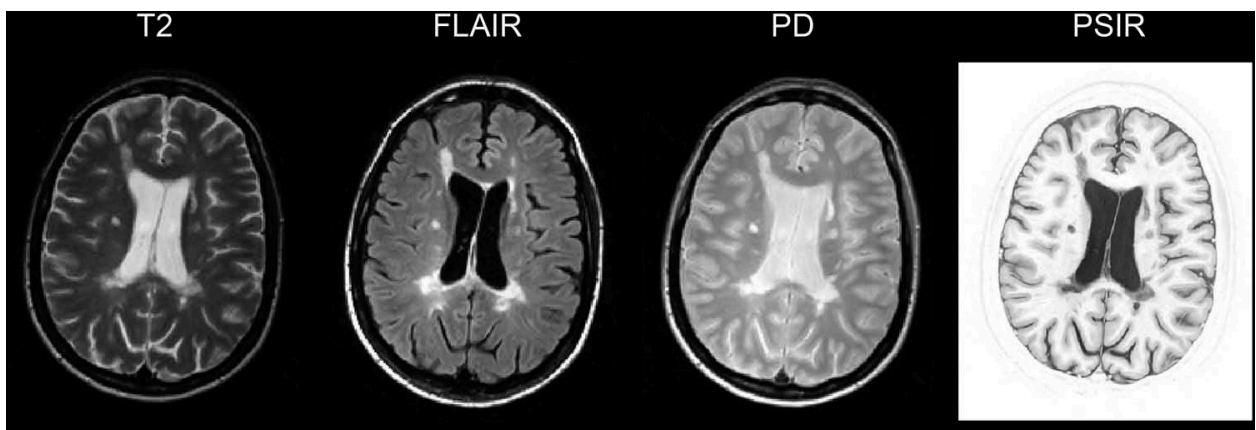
Axial MRI scan showing lesions in the same slice from the same patient with relapsing-remitting multiple sclerosis. FLAIR: fluid attenuated inversion recovery. PD: proton density. PSIR: phase sensitive inversion recovery. Figure from (Brown and Chard, 2016)
